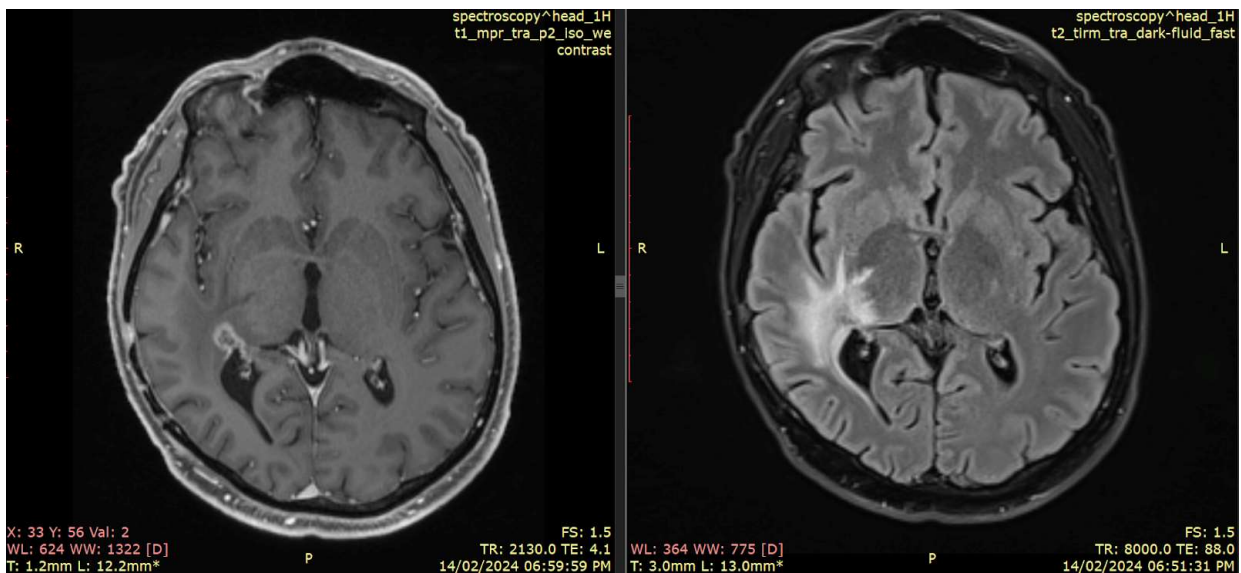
MRI from February 2024 showing an occipital lesion in close contact with the lateral ventricle. Left: T1 weighted image. Right: T2 weighted image
